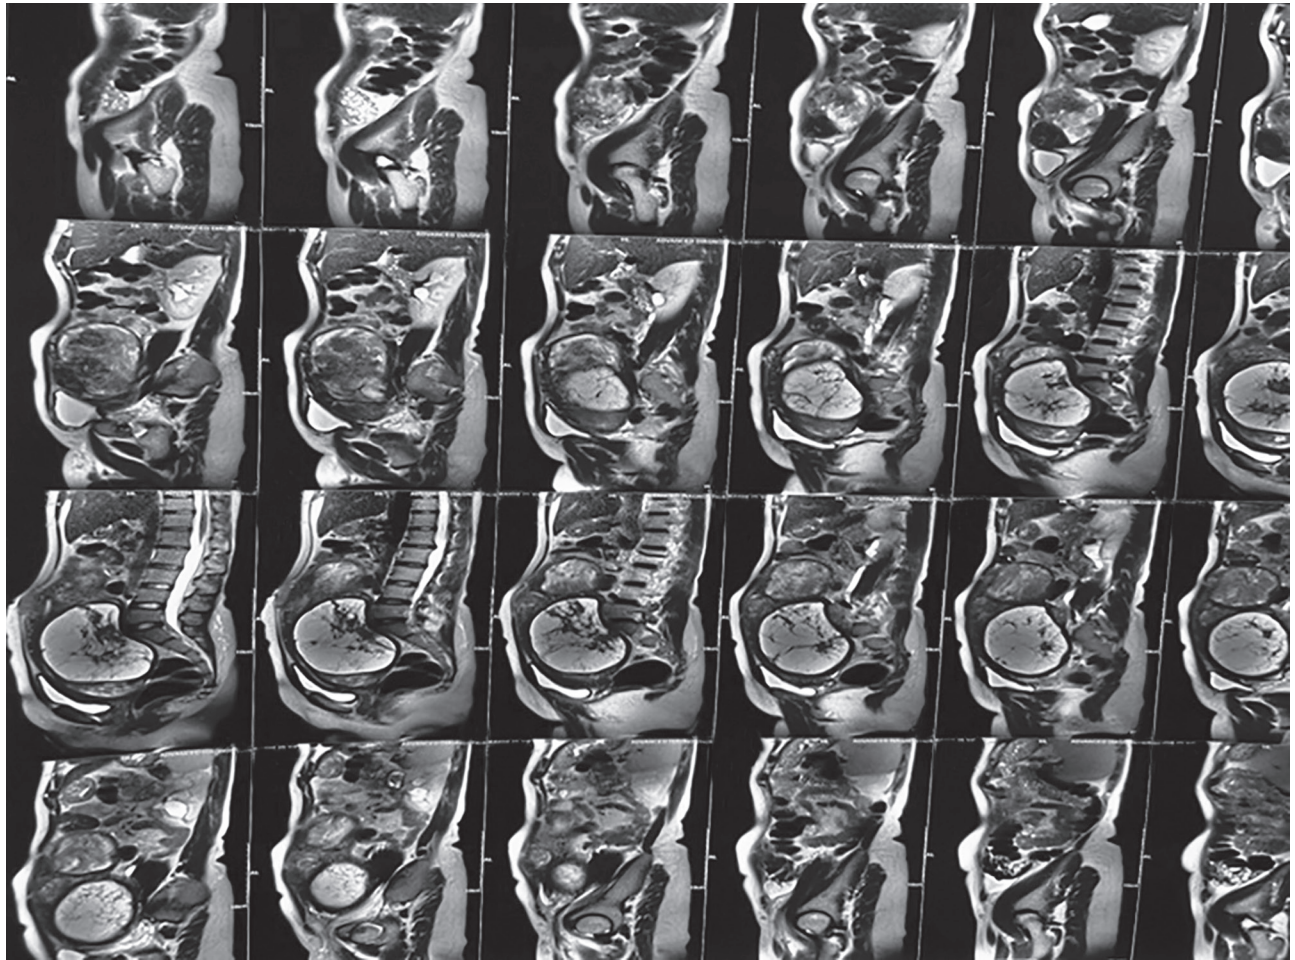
MRI-multiple moderate sized, lobulated lesions, well defined and smooth lesions present, largest measuring 120 × 93 × 127 mm, suggestive of bulky uterus with cystic degeneration with mild hydronephrosis
